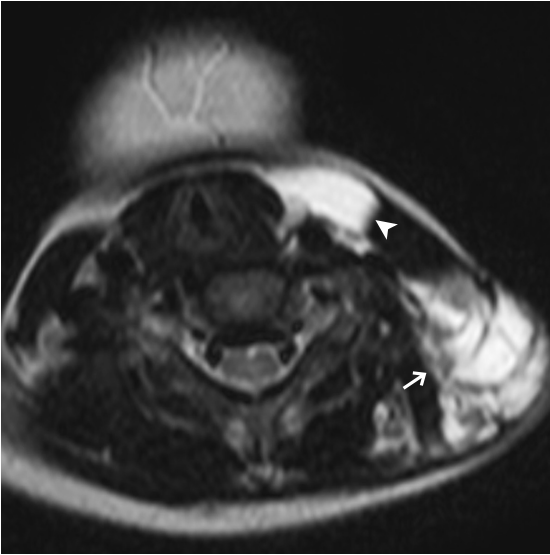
Axial T2W MRI of neck shows an infiltrative multiloculated transpatial cystic lesion (→) centered in the left posterior triangle with extension to the left submandibular region (▲). The lesion also extends inferiorly into the anterior mediastinum (not shown). In a child, the appearances are classical for a lymphatic malformation (also known as cystic hygroma).
